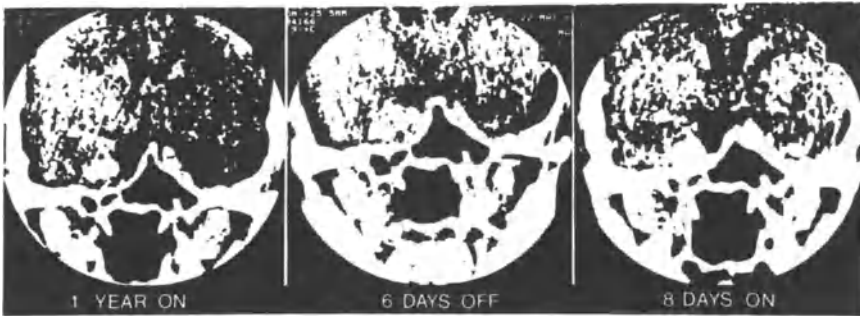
Coronal sections of CT scan through the sella turcica; at 1 year of bromocriptine treatment (left) in a young woman with a prolactin-secreting macroadenoma. There is a partially empty fossa and some residual tumour in the cavernous sinus. 6 days after bromocriptine withdrawal (centre) the tumour has re-expanded to fill the pituitary fossa, and 8 days after re-starting therapy (right) the tumour size had decreased towards the pre-withdrawal value. Reproduced with permission from reference 28
